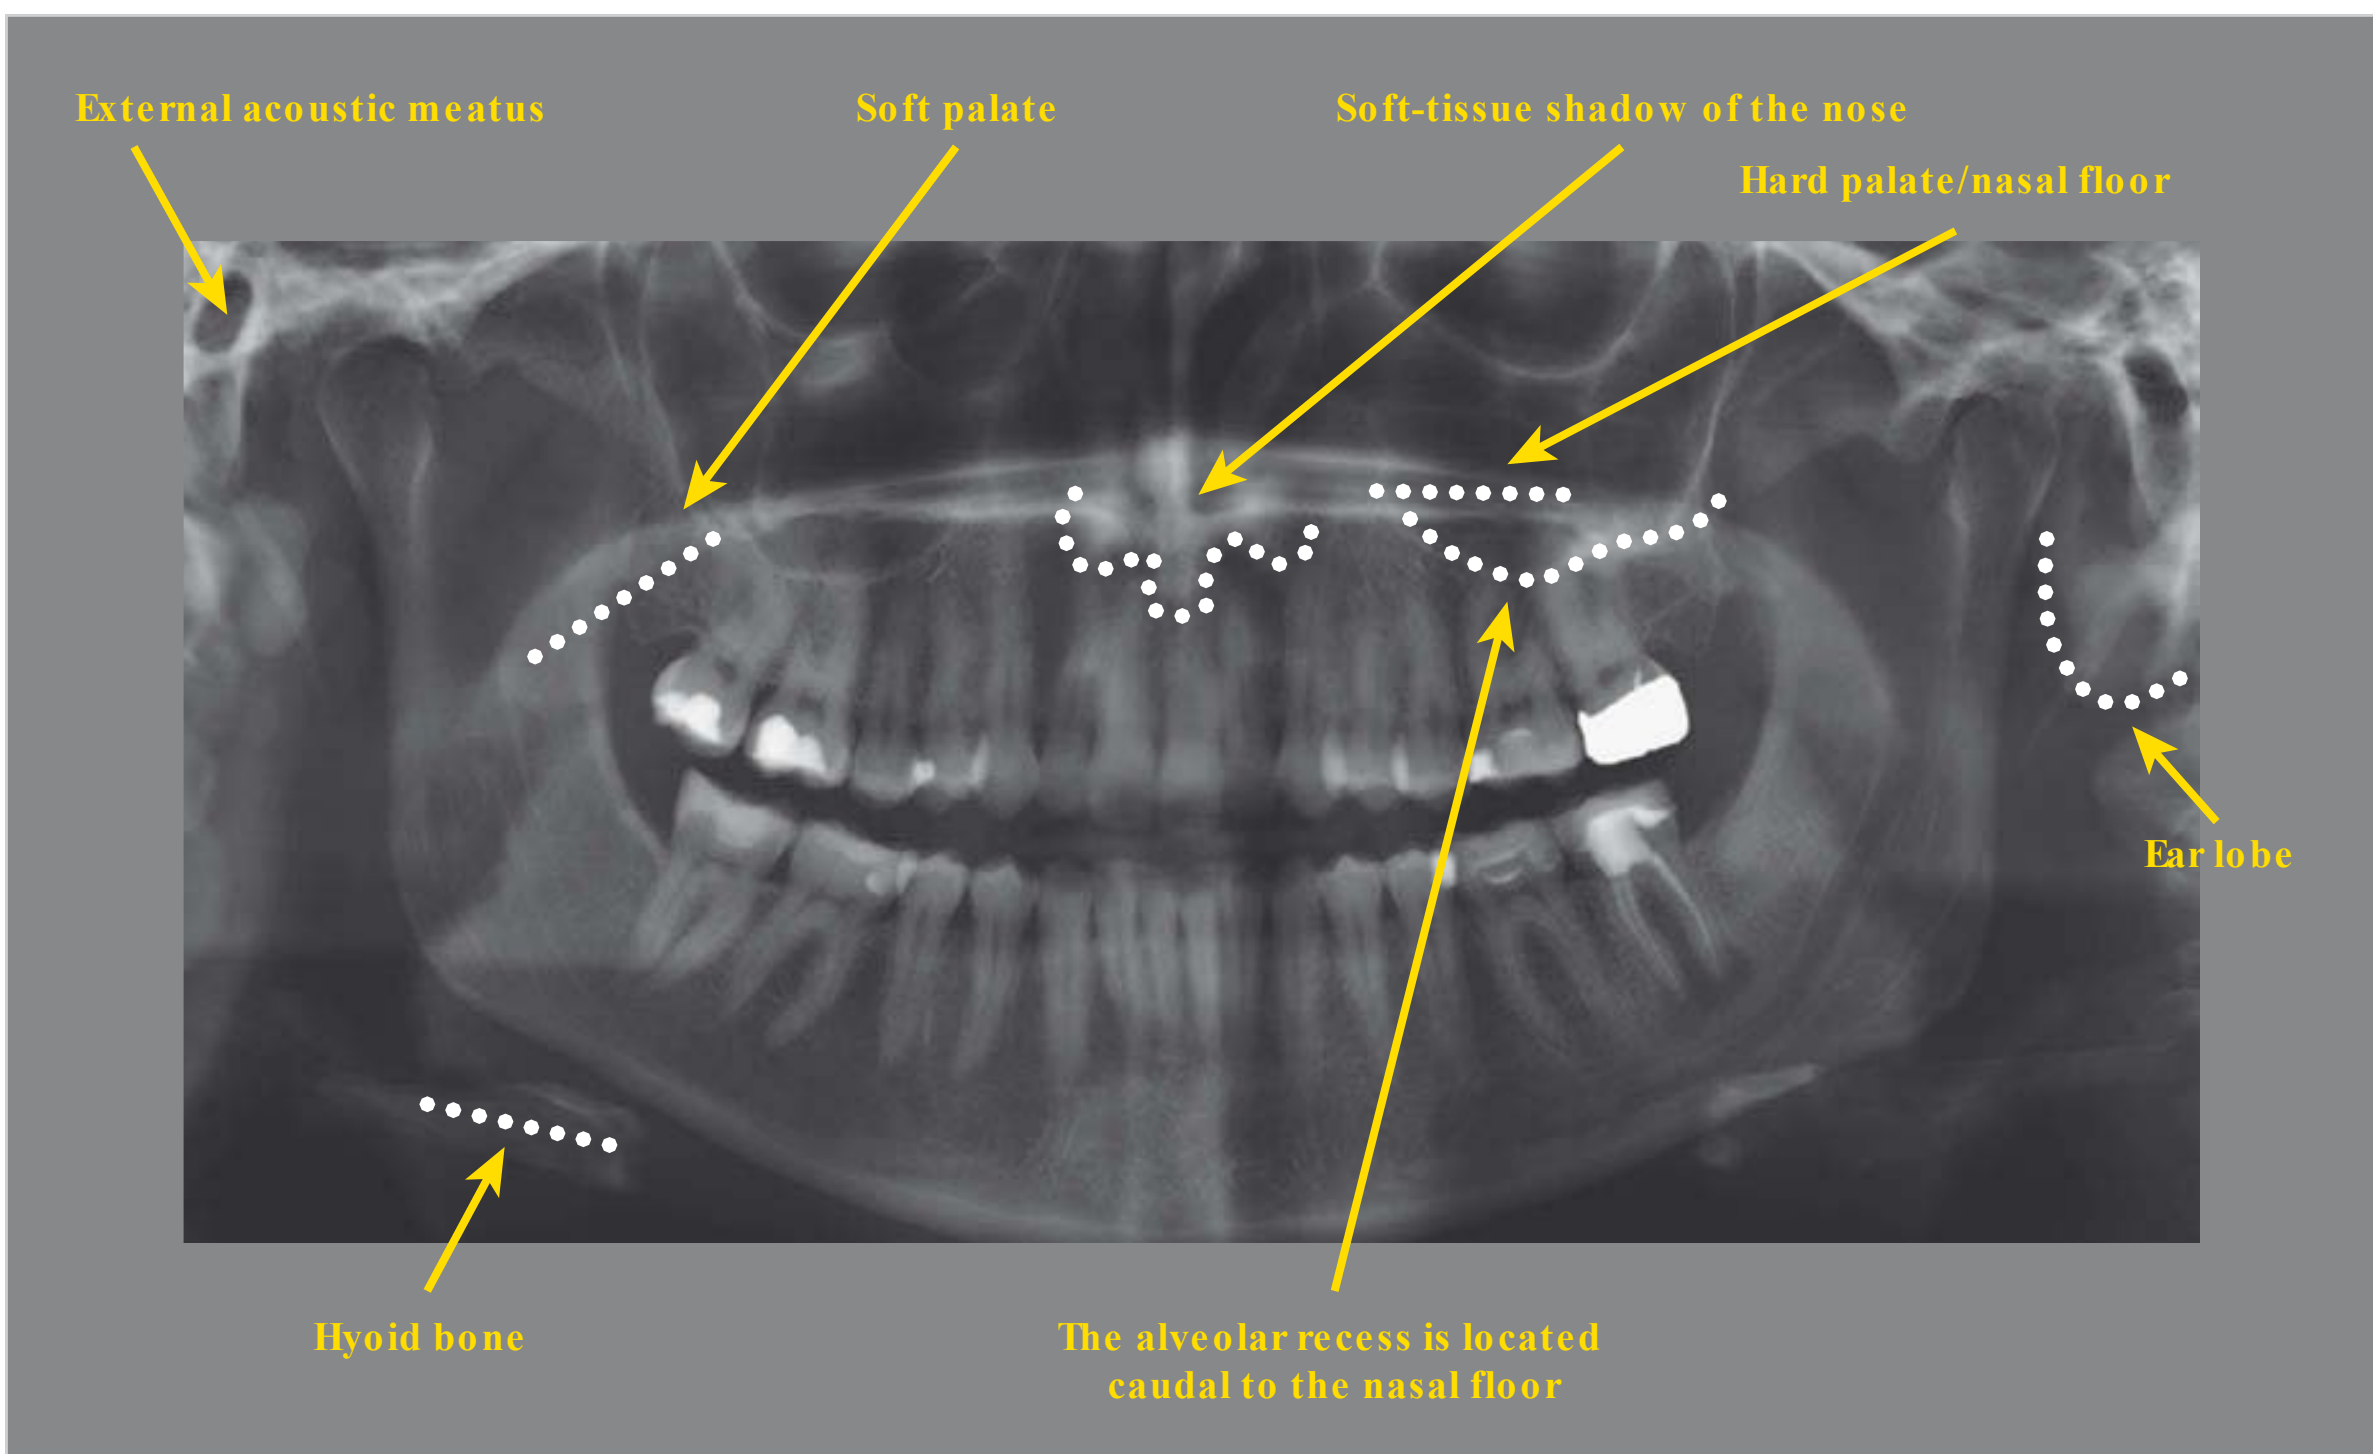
Panoramic radiography: anatomical structures I.
